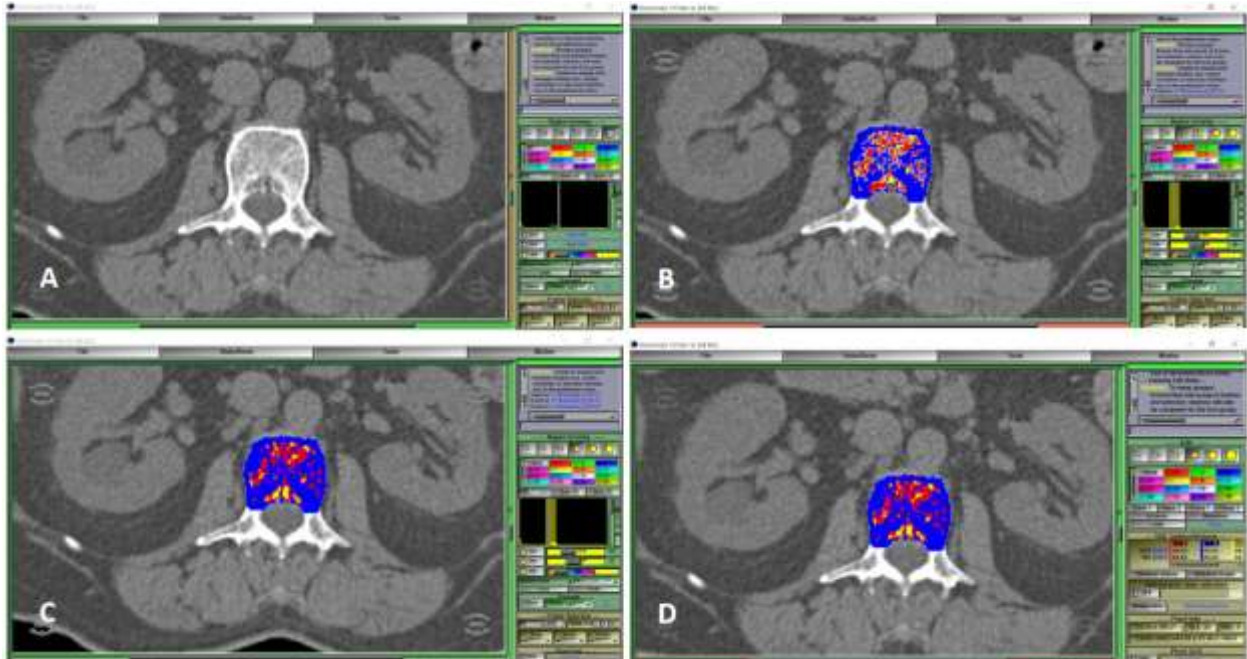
(A-D) CT image analysis of bone using SliceOmatic. (A) Image opened, arbitrary colours chosen to represent ROIs and initial thresholds entered for ROI. (B) Autosegmentation of ROIS (C) Thresholds of the signal intensity for bone (blue) fat (yellow) and bone marrow (red) were manually adjusted by visual inspection of individual pixels (D) Volume was quantified once all regions coloured.
